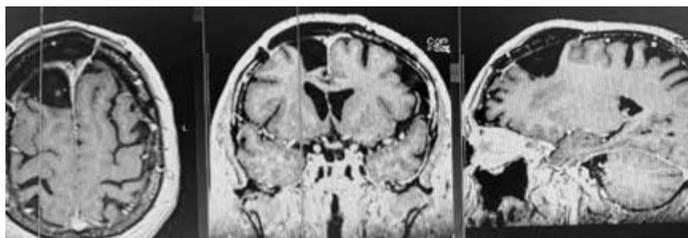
Postoperative MRI postcontrast series showing maximal surgical removal without any complicating features
